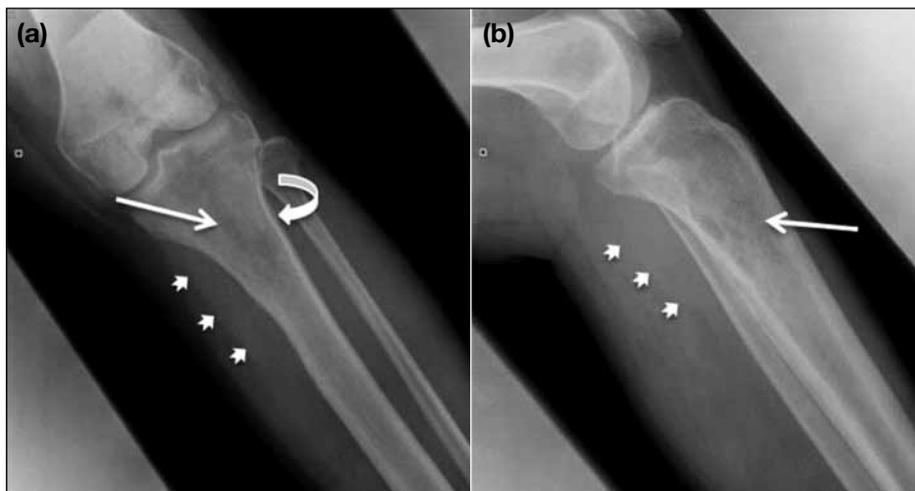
(a) Frontal and (b) lateral radiographs of left leg: a large ill-defined osteolytic lesion with wide zone of transition (arrow) is noted in the proximal meta-diaphysis of the left tibia. Extra-osseous soft tissue mass (arrowheads) and pathological fracture (curved arrow) are identified. No periosteal reaction or matrix calcification is demonstrated.
